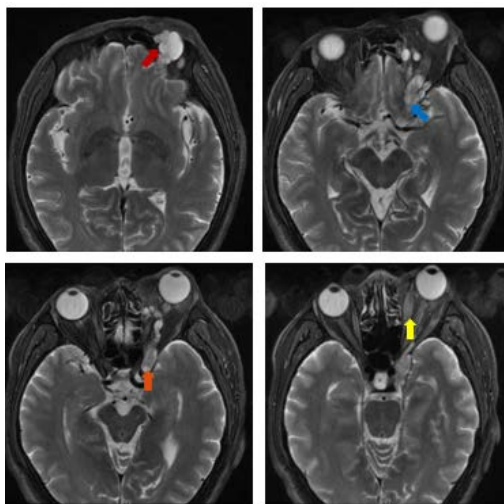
Orbital MRI: Multiple lesions are seen in the left intraorbital (red arrow), pterygopalatine fossa (blue arrow) and cavernous sinus (orange arrow), along the neuroforaminal tract, adjacent bone compression and resorption, thickening of the left extraocular muscle (yellow arrow)
